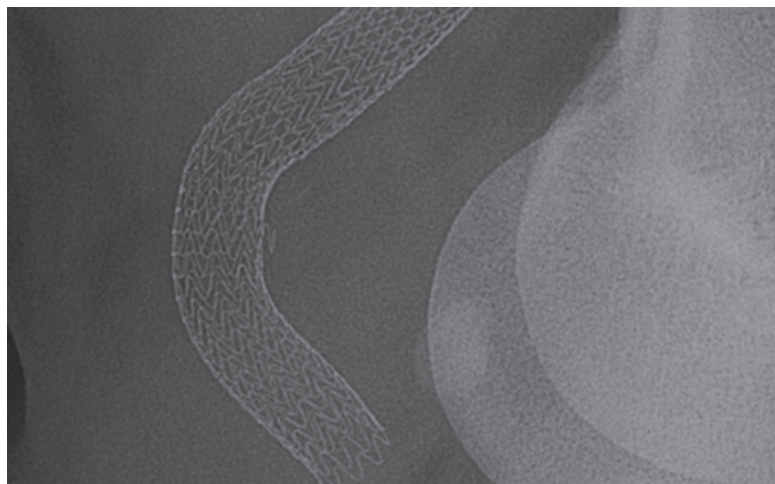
Lateral view radiograph shows a localized disruption of the stent-graft.
